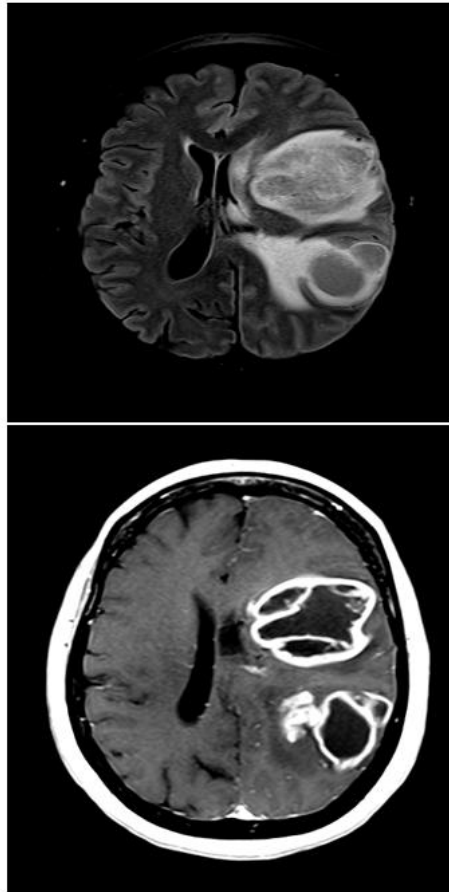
MRI Brain with/without contrast showing multiple intra-axial masses of left cerebrum abutting left lateral ventricle. Given history of NC findings may reflect changes of NC with cerebritis. Moreover, masses showing diffuse edema and 12 mm right midline shift with subfalcine and left uncal herniations.
